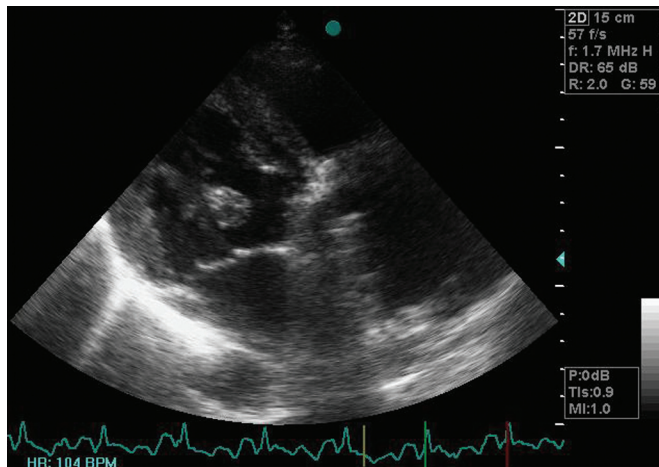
Two-dimensional transthoracic echocardiogram revealing a large homogenous mass (30 × 19 mm) on the left ventricle lateral wall.
